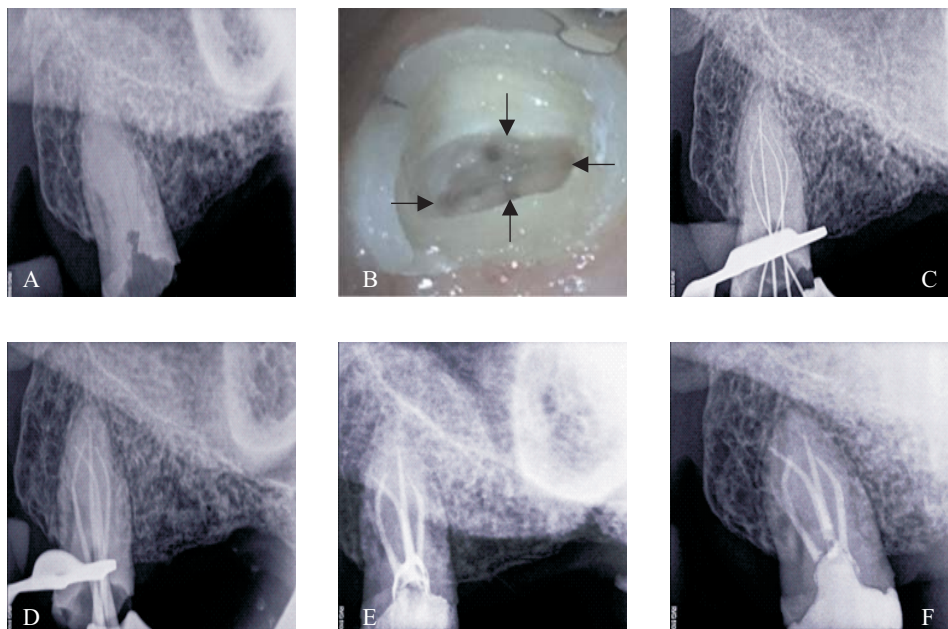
Preoperative radiograph, B: Access cavity preparation showing 4 canal orifices, C: Working length radiograph, D: Master cone radiograph, E: Postobturation radiograph, F: Post endodontic restoration
